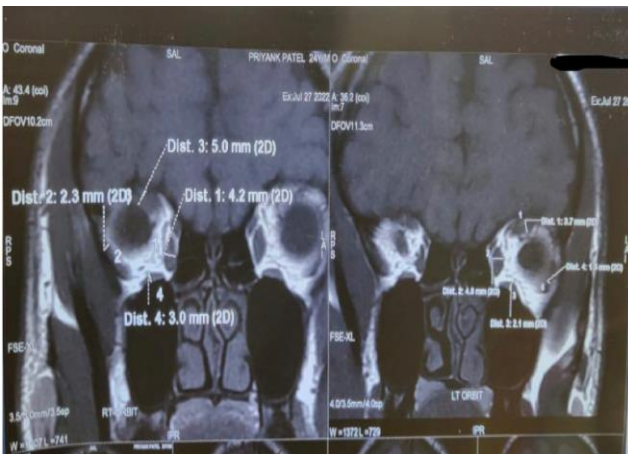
Case 1 MRI showed inferior displaced IR and nasal shift of SR.
